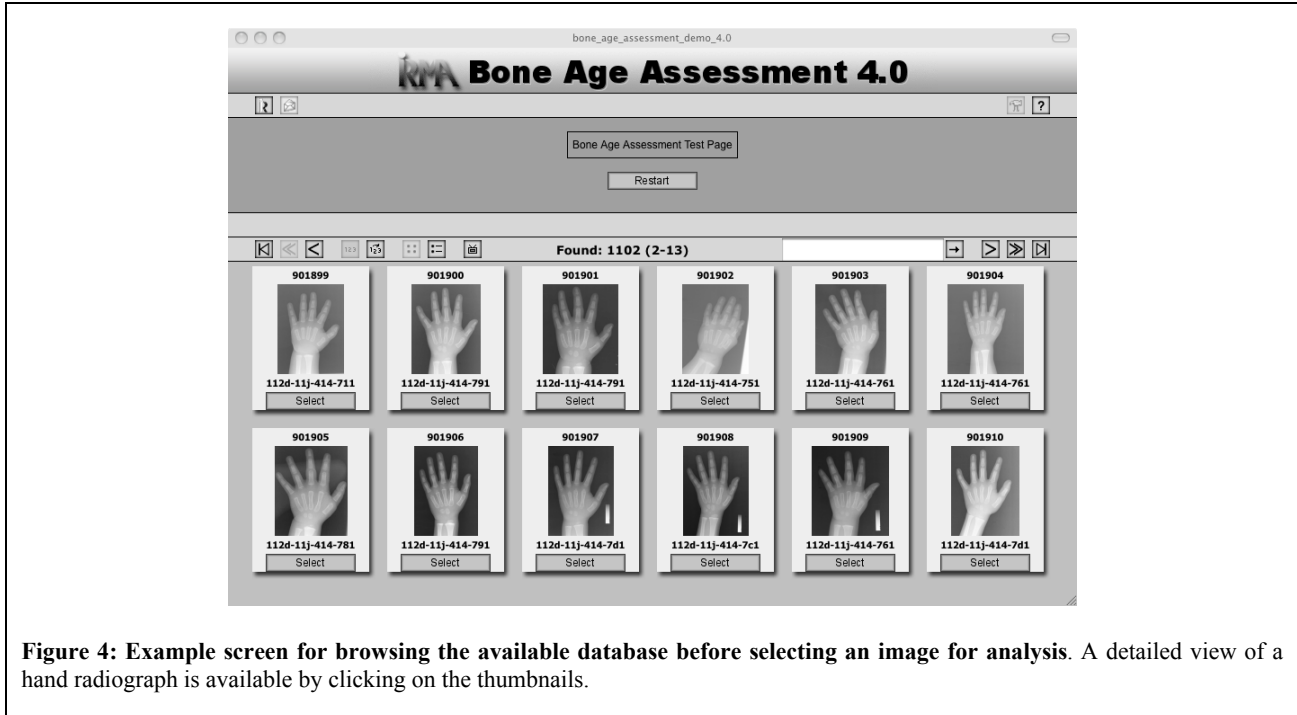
Example screen for browsing the available database before selecting an image for analysis. A detailed view of a hand radiograph is available by clicking on the thumbnails.
